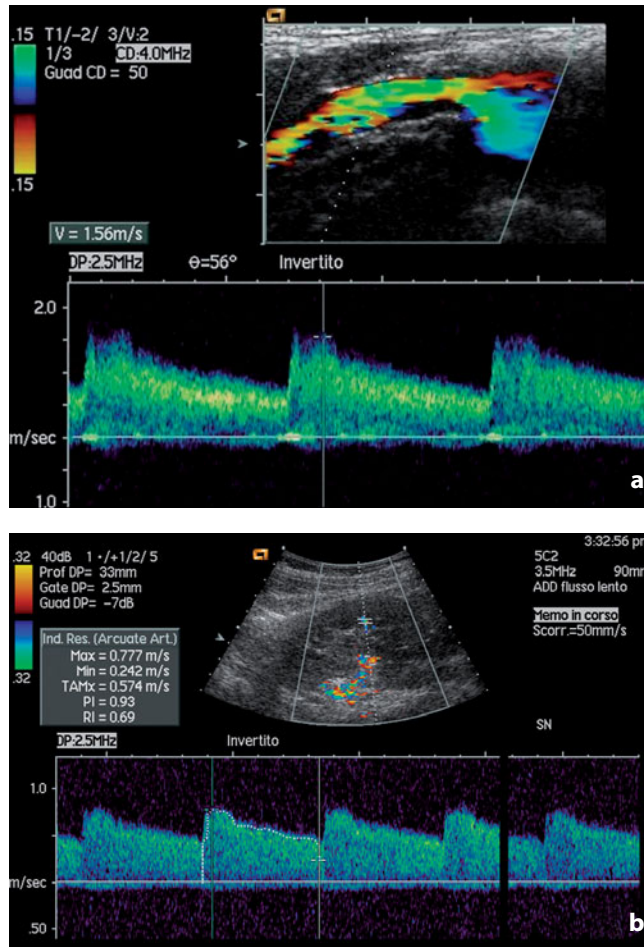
Doppler trace. Renal artery, young male subject. a The image shows the systolic and diastolic components of flow. b Intraparenchymal vessels. The resistance index (0.69) is the range of normal
